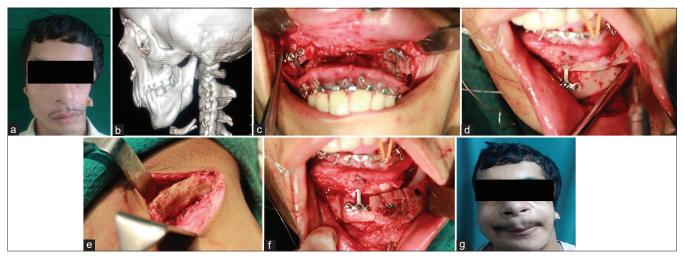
(a) Gross facial asymmetry with arrested growth of the left side of face and preauricular skin tags, (b) computed tomography showing arrested growth of left mandible, (c) Le Forte I osteotomy and correction of canted occlusal plane, (d) sliding genioplasty, (e) harvesting bone graft from iliac crest, (f) augmentation of hypoplastic left mandible with graft, and (g) post-operative image.
